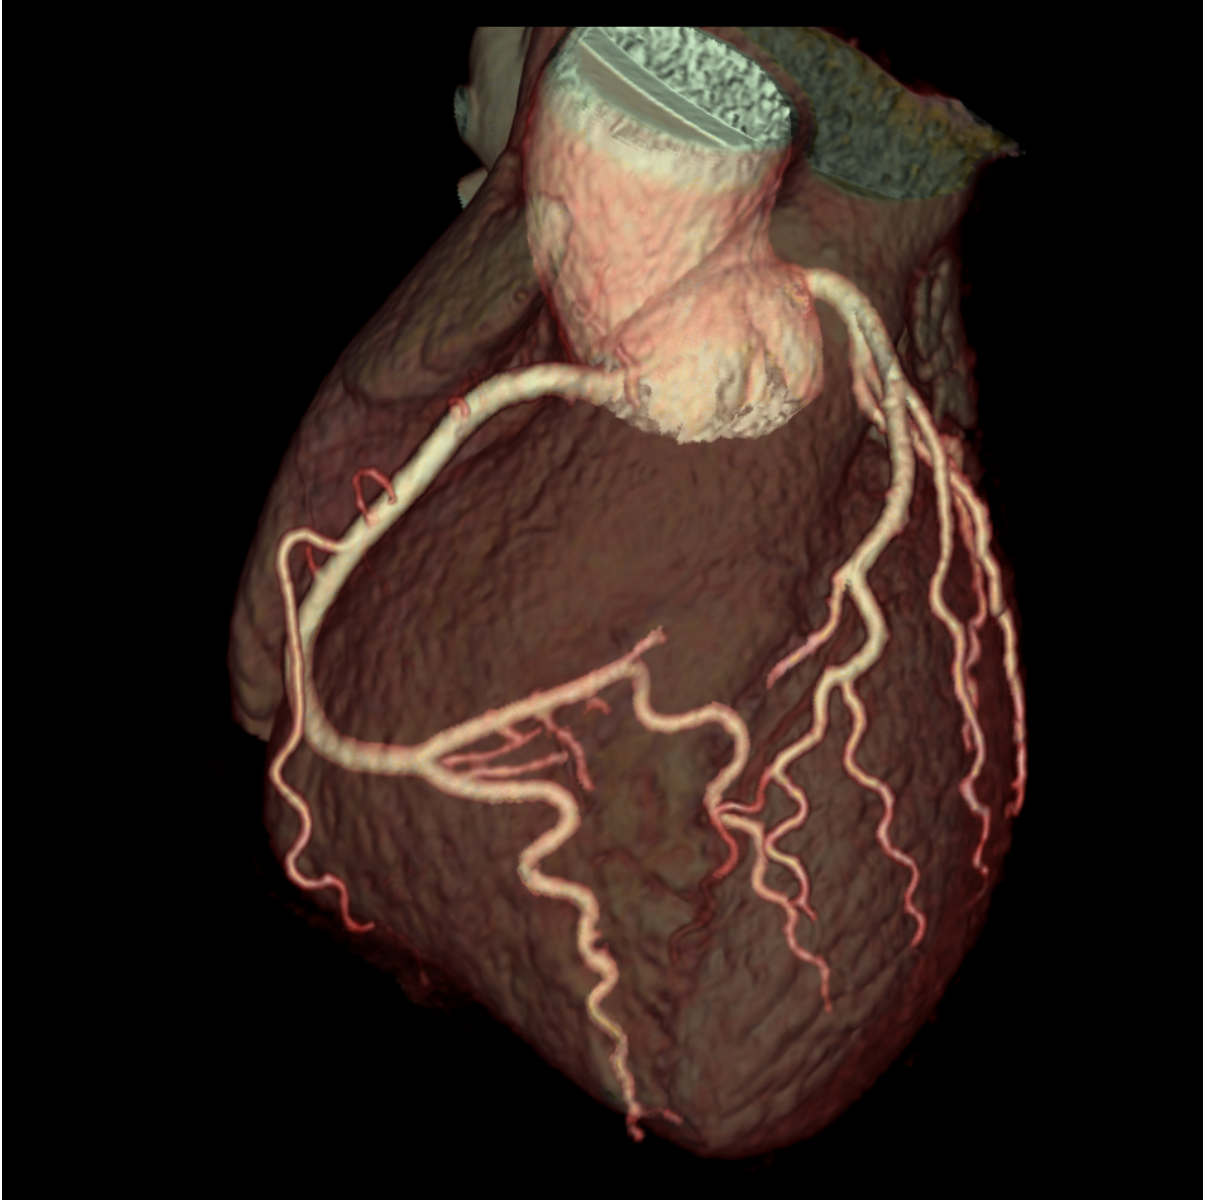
Cardiac low dose coronary artery map derived from a surface reconstruction from a 3D acquisition using the GE Revolution CT Scanner (GE Medical Systems, Waukesha, WI)
